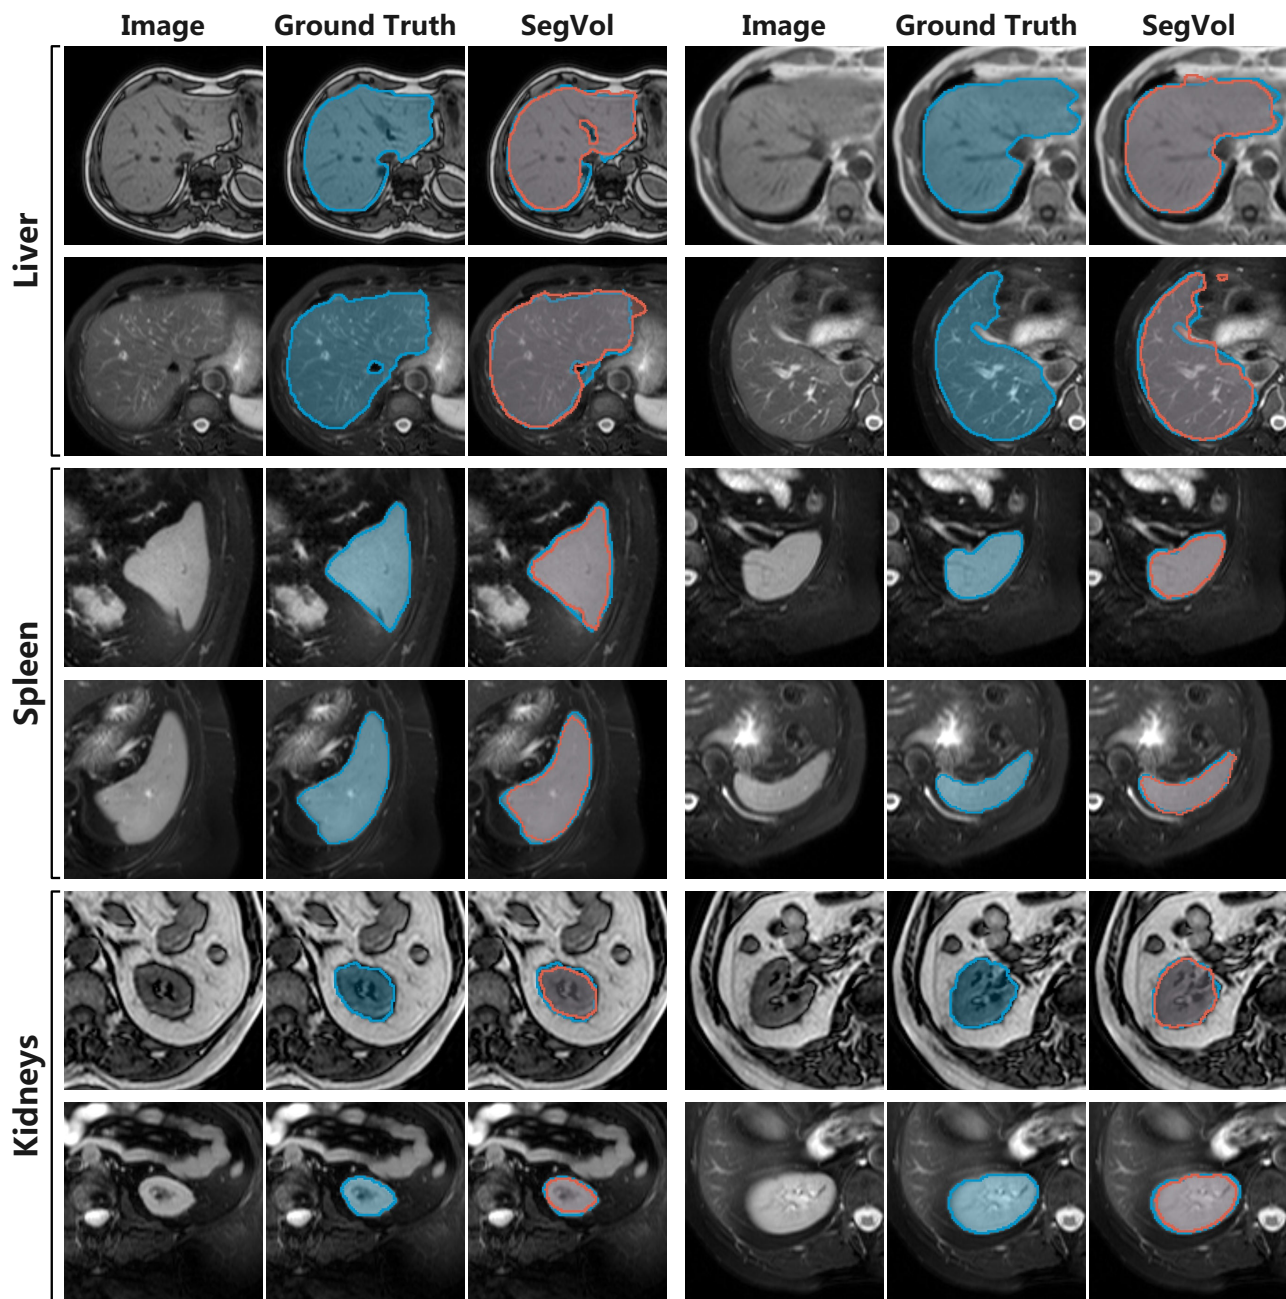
Visualized liver, spleen and kidney prediction results of SegVol on 12 cases from MRI set of CHAOS [28–30]. For unseen MRI modality, SegVol is still able to segment these four organs relatively accurately.
